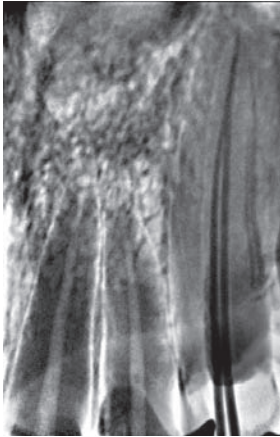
Radiograph showing working length of Master cone Gutta-percha
